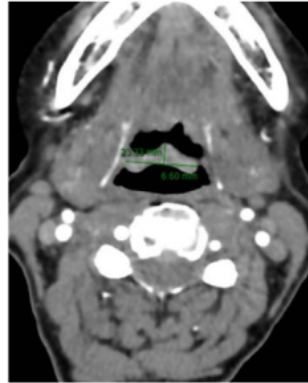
Female 74-year-old patient. Computed tomography in axial showed tumor in the epiglottis. Pathology showed squamous cell carcinoma.
